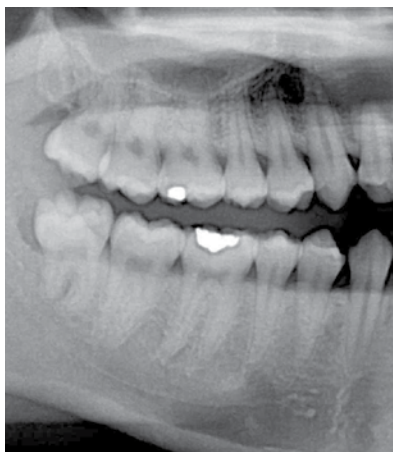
X-ray showing amalgam fillings (light parts)
